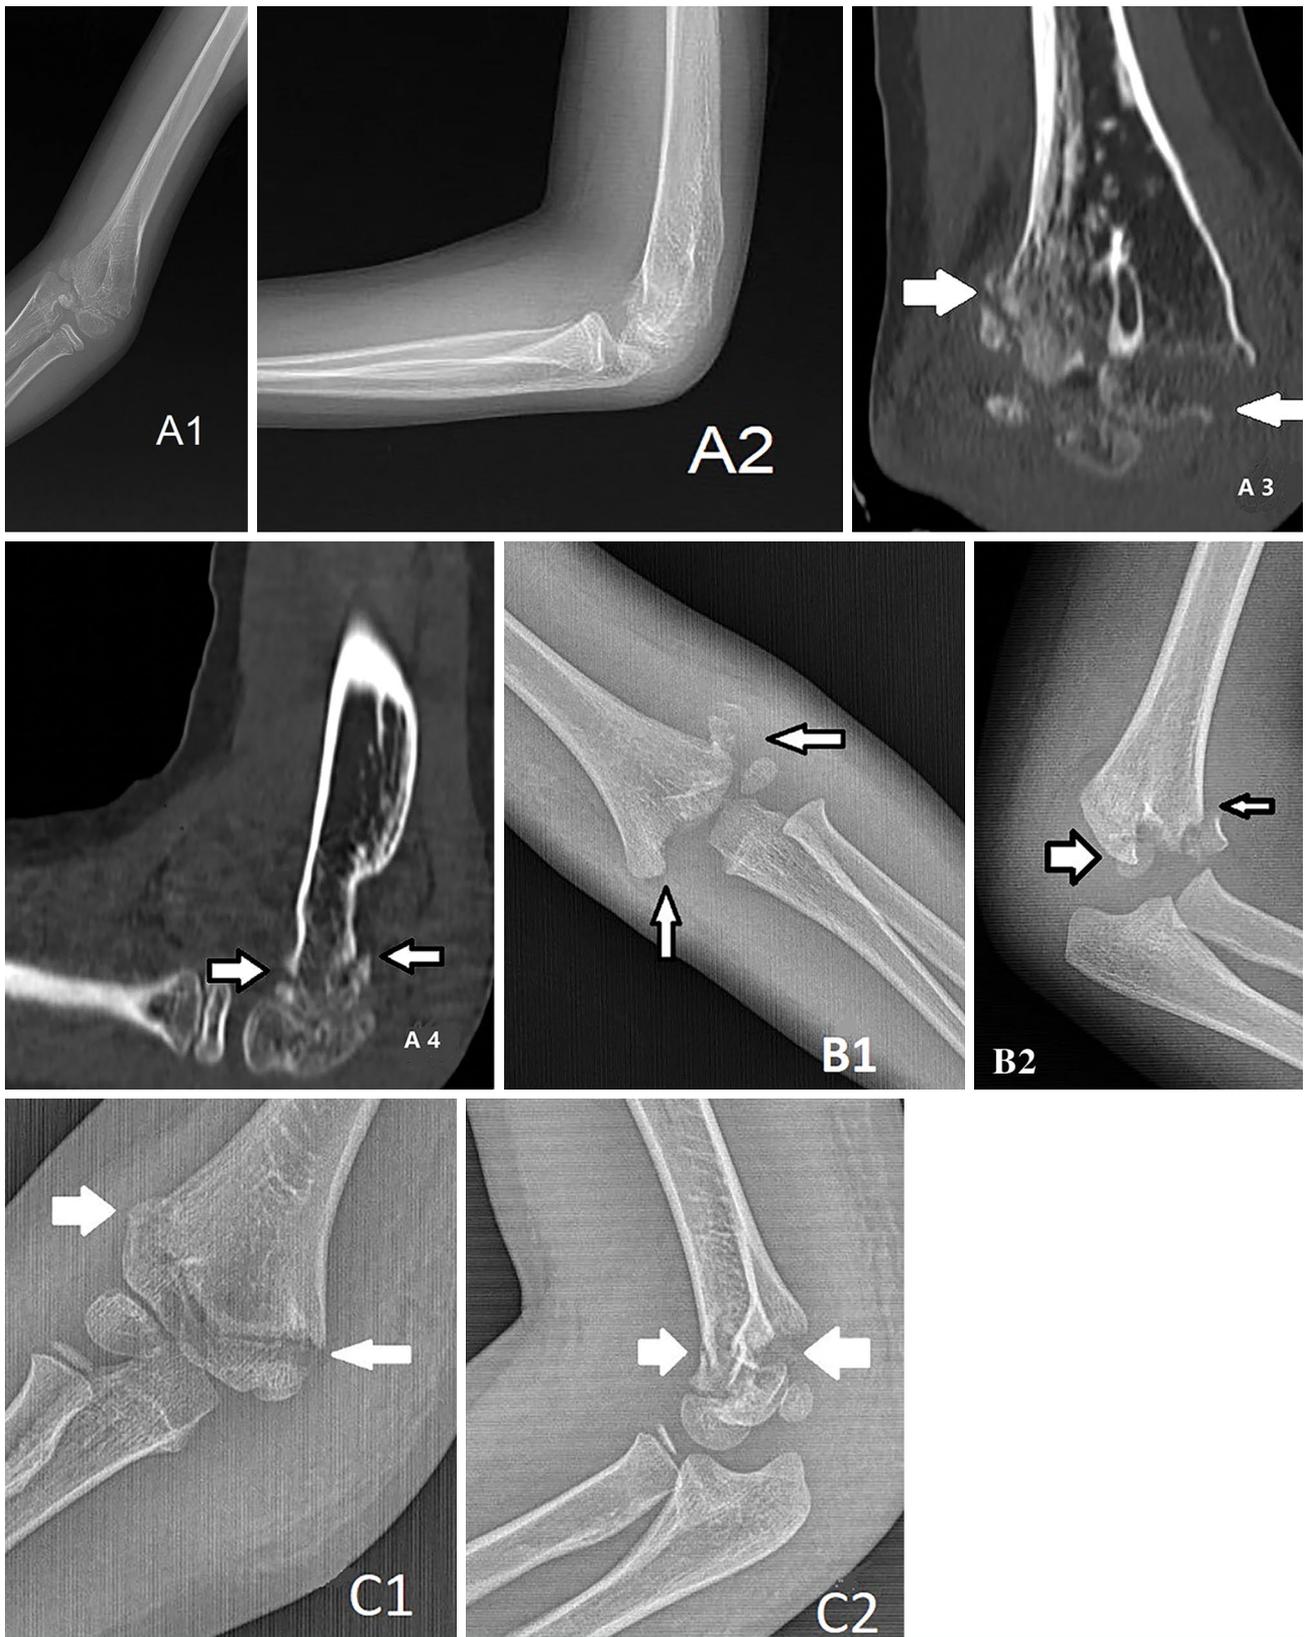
(A1) Anteroposterior and (A2) lateral radiographs of Patient 1 (A3) Coronal and (A4) sagittal computed tomography image of Patient 1. (B1) Anteroposterior and (B2) lateral radiographs of Patient 2. (C1) Anteroposterior and (C2) lateral radiographs of Patient 3.
